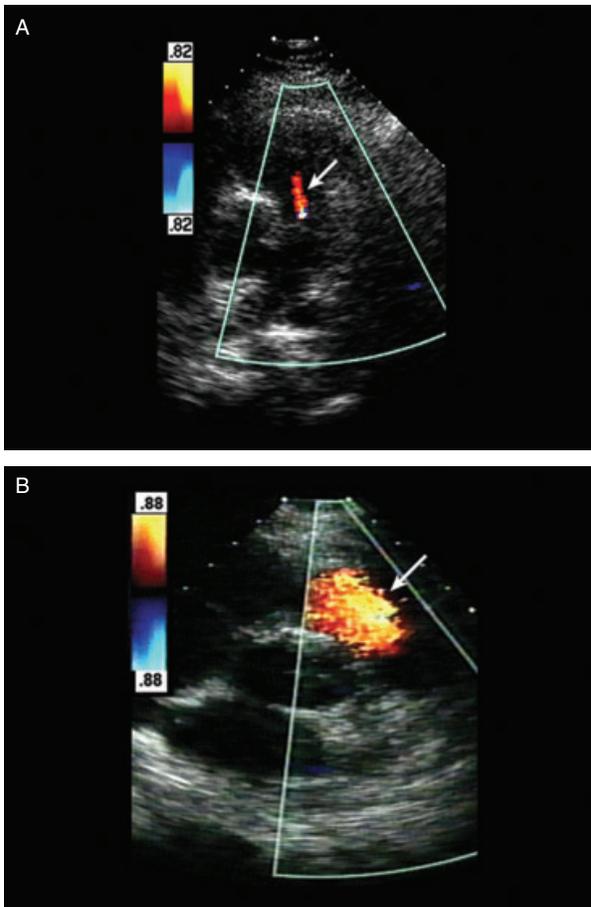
Parasternal short axis transthoracic echocardiographic images demonstrating diastolic color flow Doppler in the right ventricular outflow tract. The red jet represents the regurgitant pulmonary flow with (A) mild and (B) severe regurgitation (arrows). Notice the difference in the width of the color flow jet.
